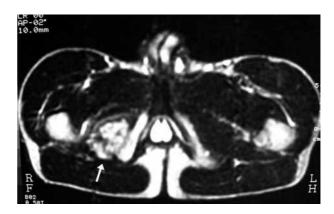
MRI showing the avulsion (arrow) as a crescent-shaped area.
